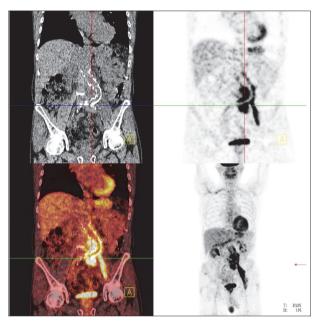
Coronal plane of unenhanced low dose CT, PET, fused PET/CT and maximal intensity projection. Focally increased uptake of FDG is showed in a projection of soft tissue lesions along vascular graft of abdominal aorta (SUVmax 9.3).
